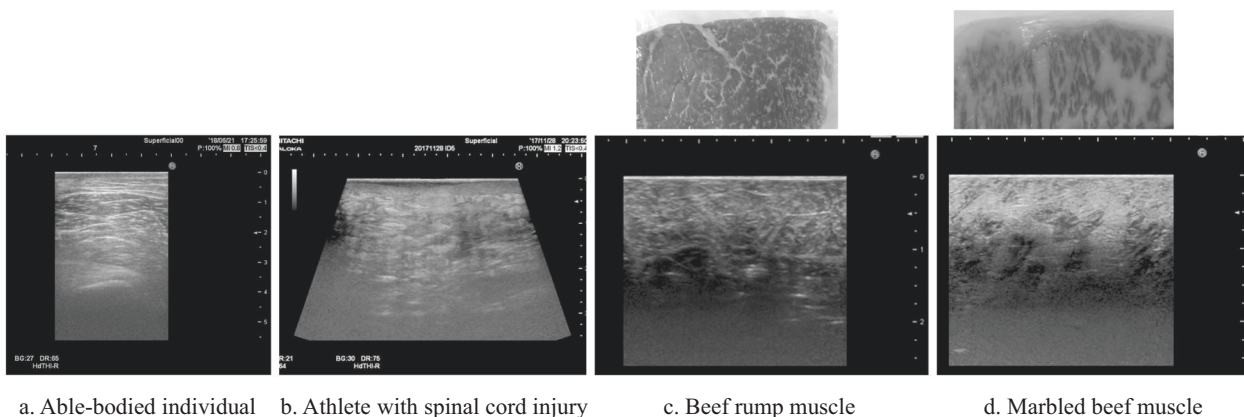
Ultrasonographic images. a The skin layer structure in ultrasonographic image of an able-bodied individual is clear. b The muscle layer is not able to be distinguished from the fat layer in this
